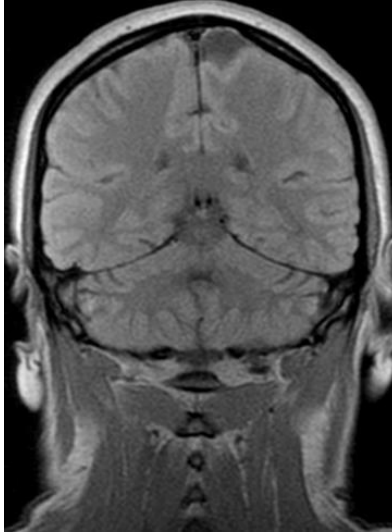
Multiple sclerosis MRI
